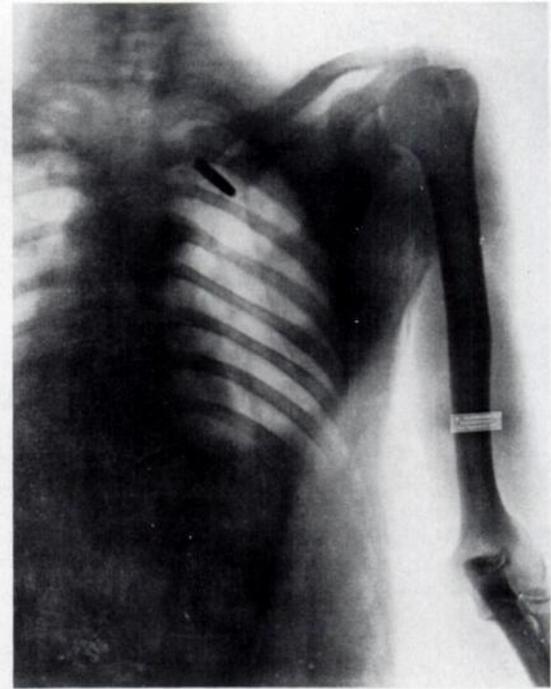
Posteroanterior chest radiograph, taken by Elizabeth Fleischman of a soldier who had been wounded during the Spanish-American War, shows a lodged Mauser bullet. (Reproduced from reference 11, plate X.)
